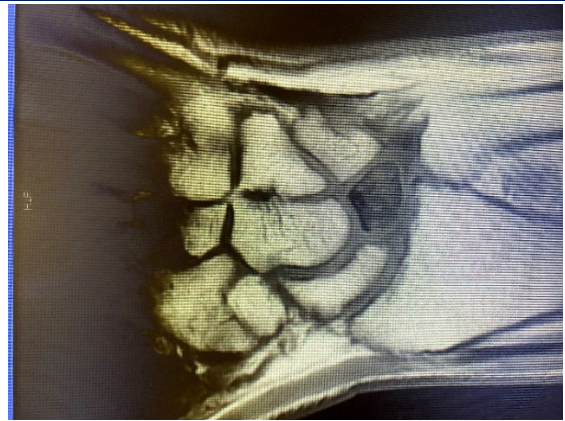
lunate avascular necrosis; a coronal MRI section
